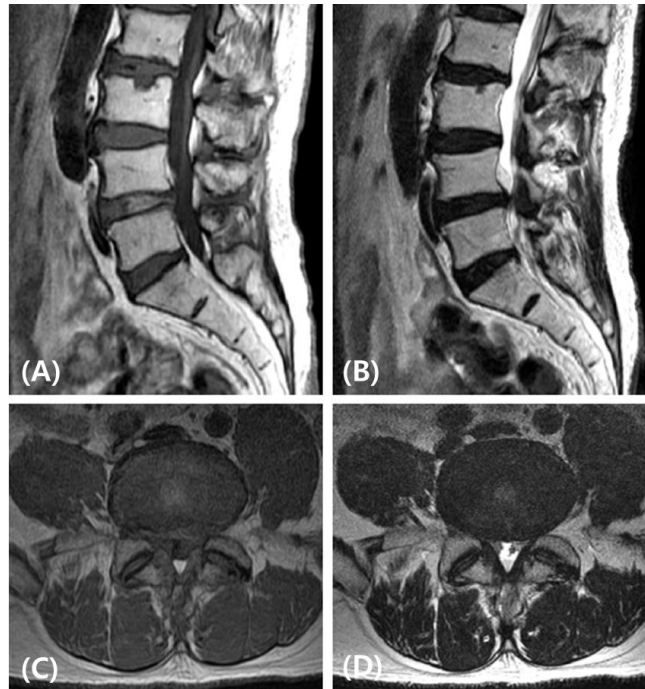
T1 and T2 weighted sagittal and axial magnetic resonance images showing diffuse bulging of the L2-3, L3-4, L4-5, and L5-S1 discs. (A and C) T1-weighted images, (B and D) T2-weighted images
